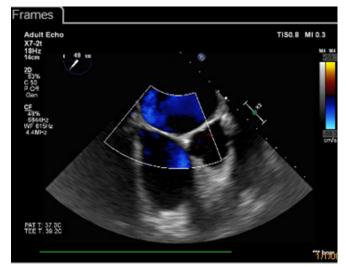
Transesophageal echocardiography. Midesophageal view at 49 degrees. Interatrial septum without any PFO.
